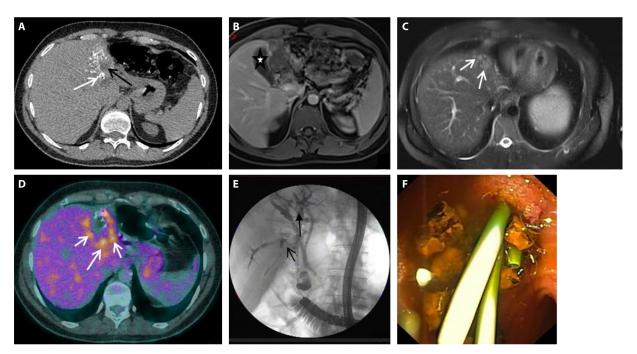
Complementarity of imaging techniques for the diagnosis and preoperative assessment of alveolar echinococcosis (AE) lesions in a patient with portal vein and bile duct invasion by the parasitic lesions. (A) On computed tomography (CT) scanning, the lesion shows the characteristic heterogeneous aspect of AE, with hyperdense calcifications (white arrow) and hypodense area (central necrosis) (black arrow). (B) Fat-suppressed T1-weighted magnetic resonance (MR) image after gadolinium injection at the portal venous phase shows an atrophy of the left liver and invasion of the left portal vein and of the left intrahepatic biliary tree. The lesion is at the contact of the gallbladder (white star) which is not invaded. (C) T2-weighted MR images show the presence of hyperintense microcysts (white arrows), pathognomonic of AE, but also a solid component (Kodama type II). (D) Fluorodeoxyglucose (FDG) uptake in positron emission tomography (PET) is markedly increased at the periphery of the lesion (white arrows). (E) Assessment of biliary tree involvement and treatment by perendoscopic stenting in a patient with late postoperative biliary complications of AE. Endoscopic retrograde cholangiopancreatography (ERCP) was performed (with a colonoscope because of previous gastrectomy), showing dilation of the extrahepatic and intrahepatic biliary tree with several defects (black arrows) because of biliary stones due to chronic biliary obstruction and bacterial superinfection. (F) Perendoscopic stenting via ERCP. After balloon dilation followed by extensive lavage with isotonic saline and stone extraction, 3 plastic stents (size, 7 and 10 French) are inserted in the stenosis of the bile duct (endoscopic view).
